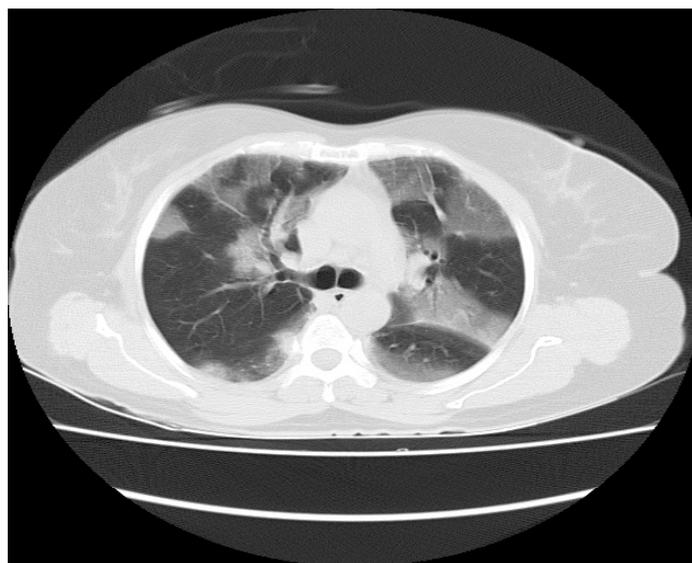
CT Chest- ground glass opacity
